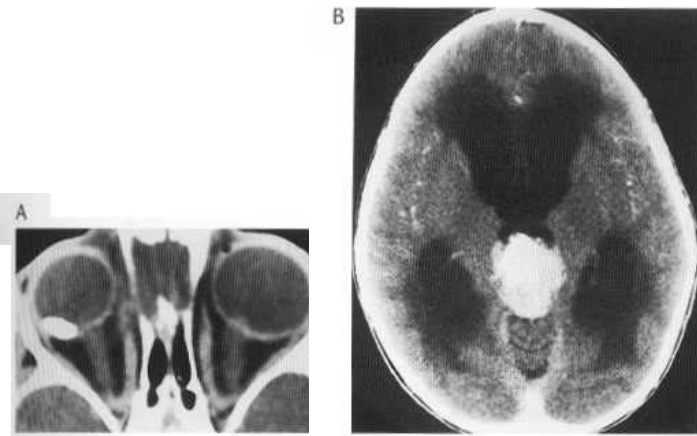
Trilateral retinoblastoma. Enhanced axial CT image (A) demonstrates large lobular calcification based on right retina. A second, smaller, retinal lesion can be seen overlying the left optic nerve head. Axial image at higher level (B) demonstrates hydrocephalus due to large enhancing mass in the region of the posterior third ventricle/pineal cistern representing pineoblastoma.
